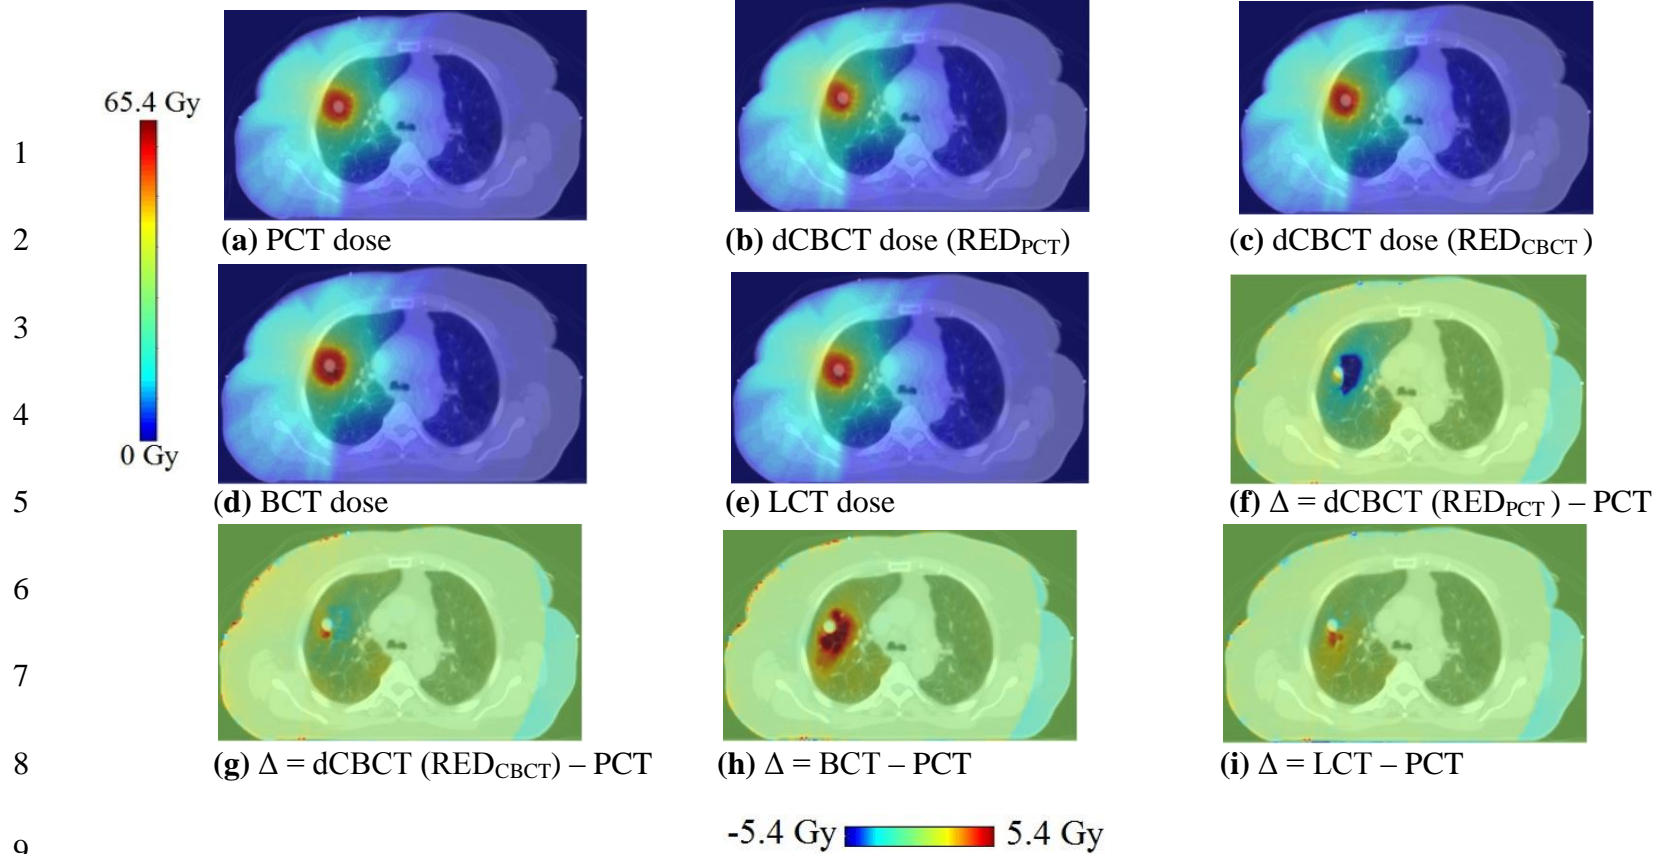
(a) - (e) shows the PCT, dCBCT, BCT, or LCT VMAT dose distributions overlaid on the PCT image. Figs. 4-8 (f)-(i) show the dose differences, Δ , overlaid on the PCT image. The largest differences occur in regions with steep dose gradients.
